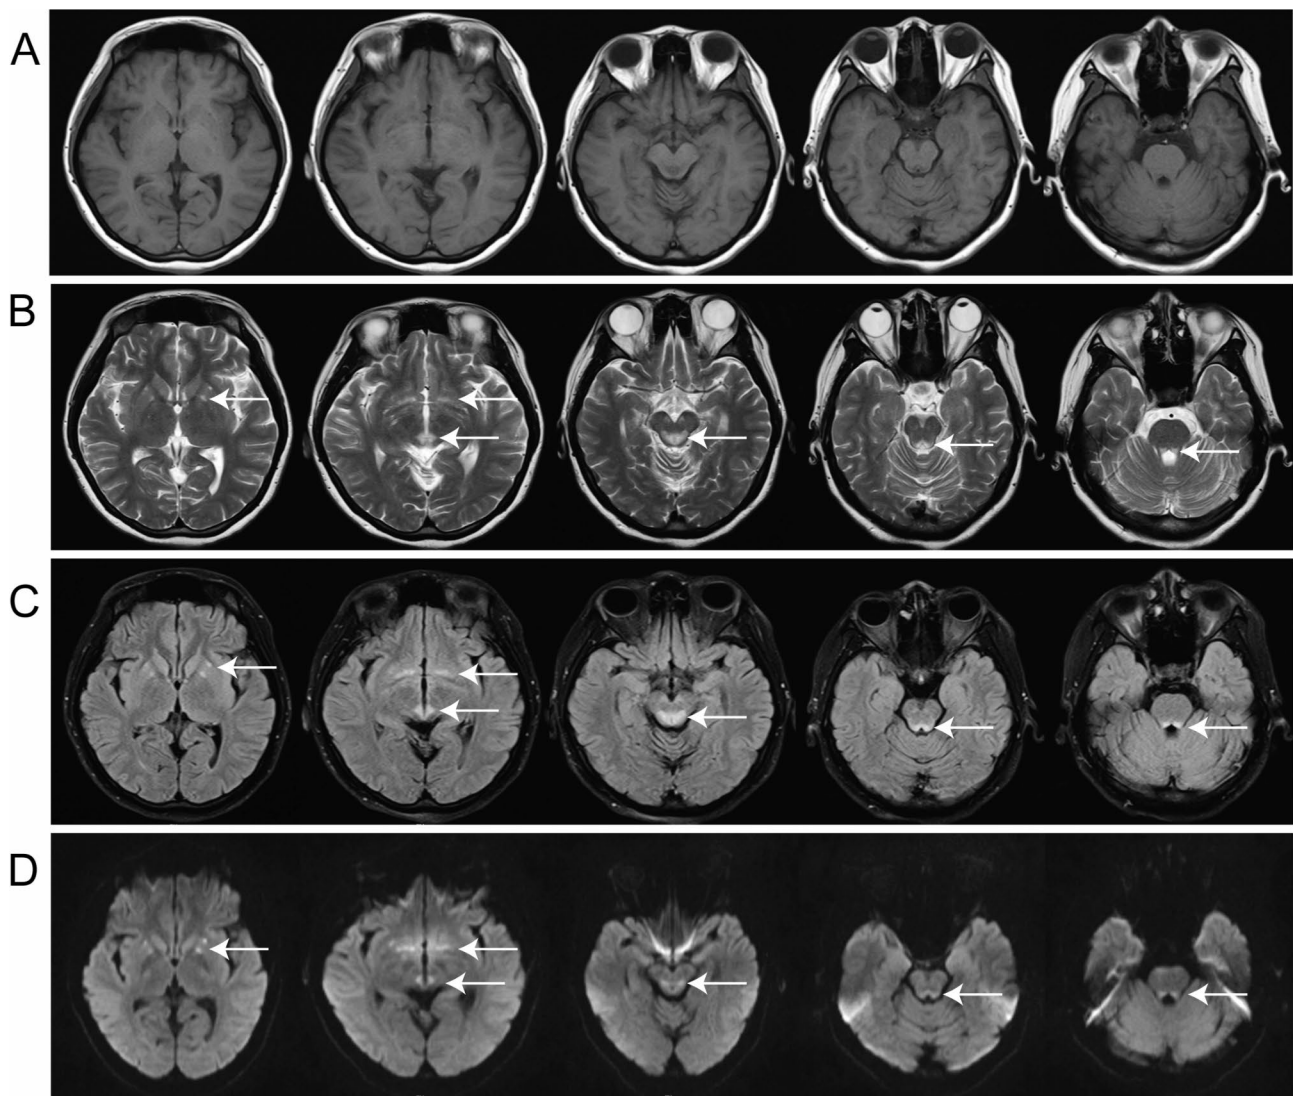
Brain MR image of the patient in October 2021 showing bilateral symmetrical lesions with abnormal signals in the dorsal brainstem, mesencephalic aqueduct and bilateral basal ganglia on T1 (A), T2 (B), FLAIR (C) and DWI images (D)
